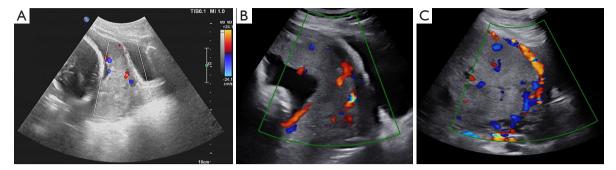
Ultrasonic sign-scoring method for the diagnosis of PA: (A) PA; (B) PI; (C) PP. TIB, thermal index for bone; MI, mechanical index; PA, placenta accreta; PI, placenta increta; PP, placenta percreta.
